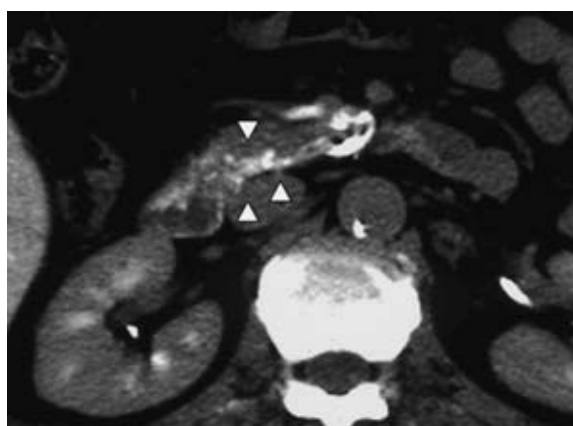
Dynamic computed tomography revealed a hypervascular lesion in the head of the pancreas and the second part of the duodenum (white arrowheads).
